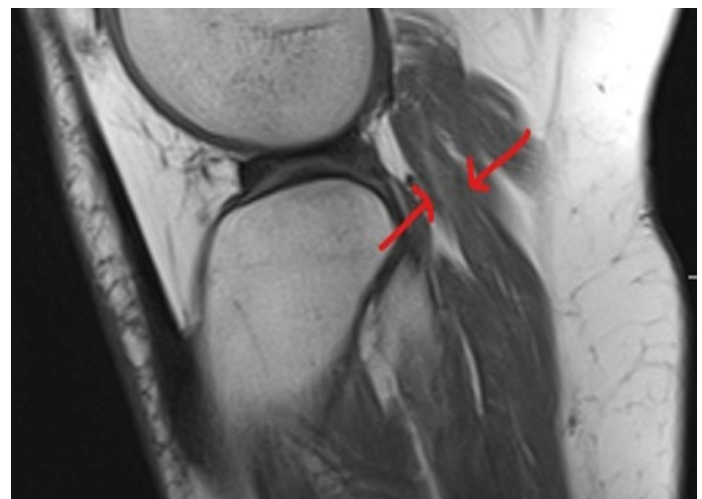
Sagittal MRI plantar muscle
